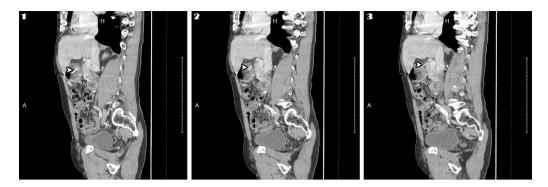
Serial reconstructed sagittal computed tomography images showing full penetration of the gastric wall by the ingested foreign body (white arrow).
